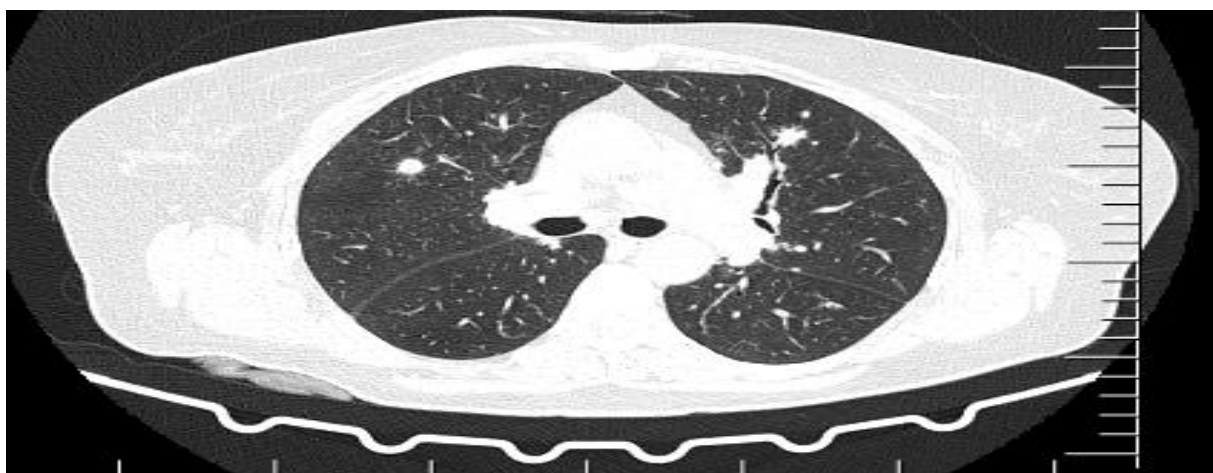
HRCT Chest peribronchovascular nodules
